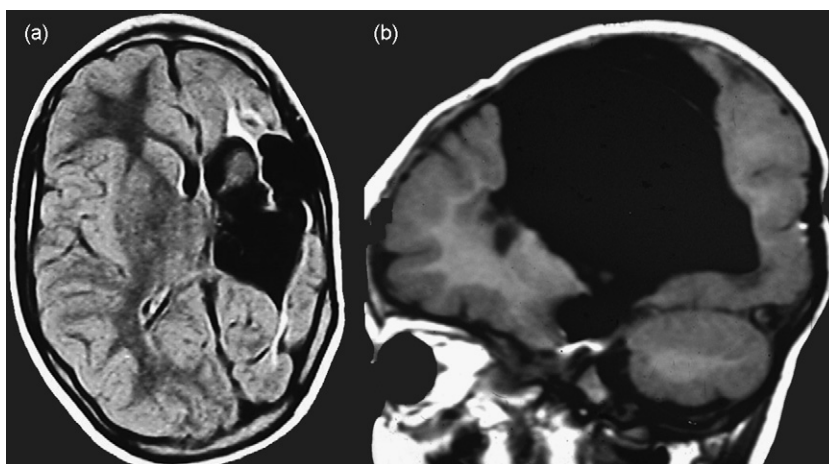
Poroencephalic cyst. (a) Preoperative axial FLAIR RM image showing extensive poro-encephalic left fronto-temporal cyst with involvement of basal ganglia region and thalamus; the left lateral cerebral ventricle and Sylvian fissure are dilated, ex-vacuo, the left hemicranium is clearly reduced in size. (b) Postoperative (functional hemispherectomy) sagittal RM T1w image.
